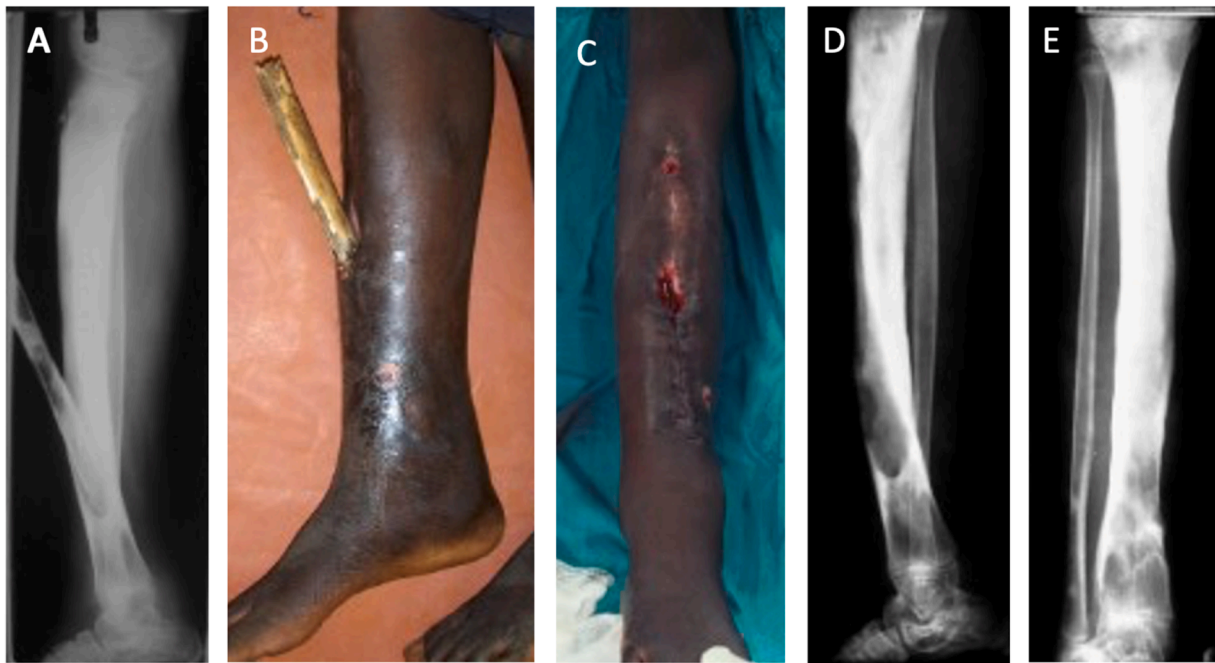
A case of tibial osteomyelitis with extruded sequestrum and moderate soft tissue involvement (A and B). With radiographic features of bone stability, a safe sequestrectomy was performed (C). The soft tissue defect following sequestrectomy was minimal and healed by primary intention. Interestingly, the sequestered mid-diaphysis was completely replaced and remodeled in the course of the natural process of the disease, without any medical or surgical intervention, just in 18 months (D and E).
